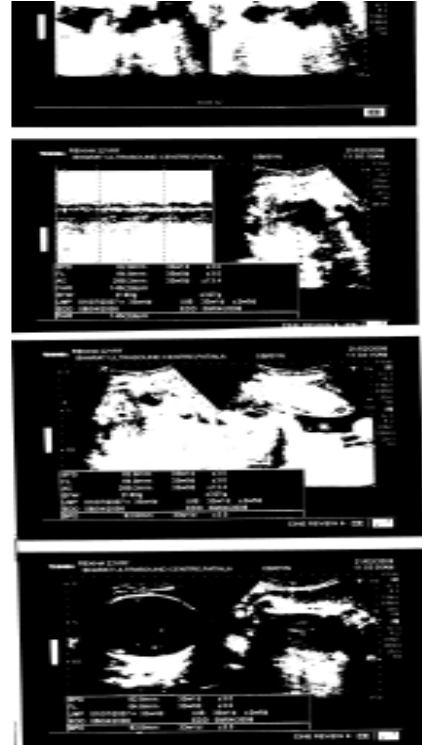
Ultrasound pictures of the subject
